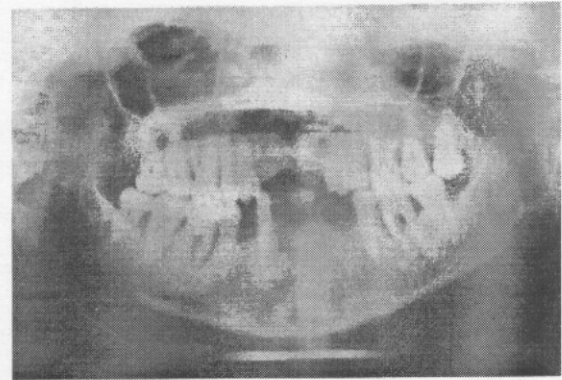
Intermediate panoramic radiografi of patient.
